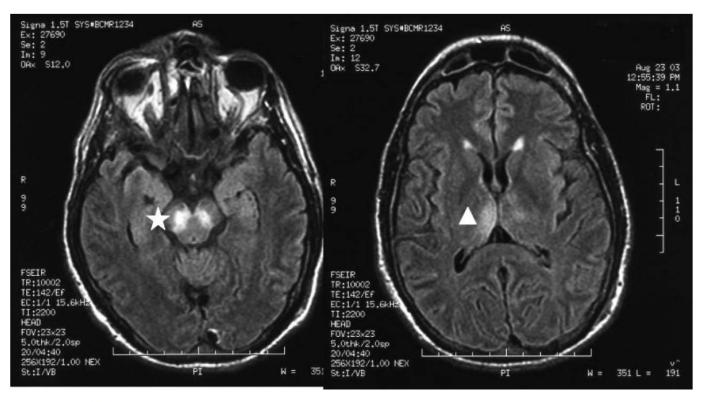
Axial T2-weighted brain magnetic resonance image of a patient with West Nile virus encephalitis and severe tremor and parkinsonism, displaying increased signal in the basal ganglia (*) and posterior thalami (Δ)
